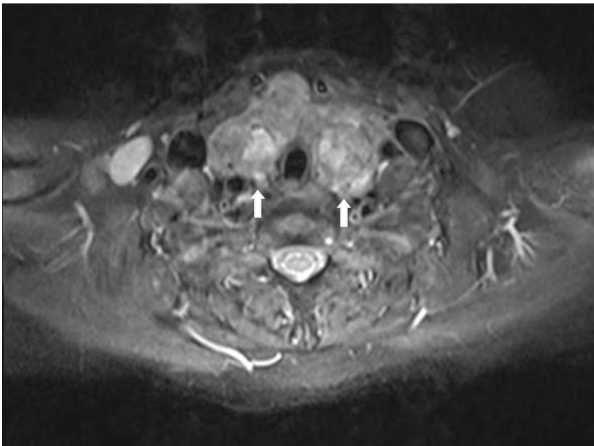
Multiple calcified nodular lesions in both thyroid lobes which seem mildly hyperintense on T2-weighted image on magnetic resonance imaging of the neck (white arrows)
